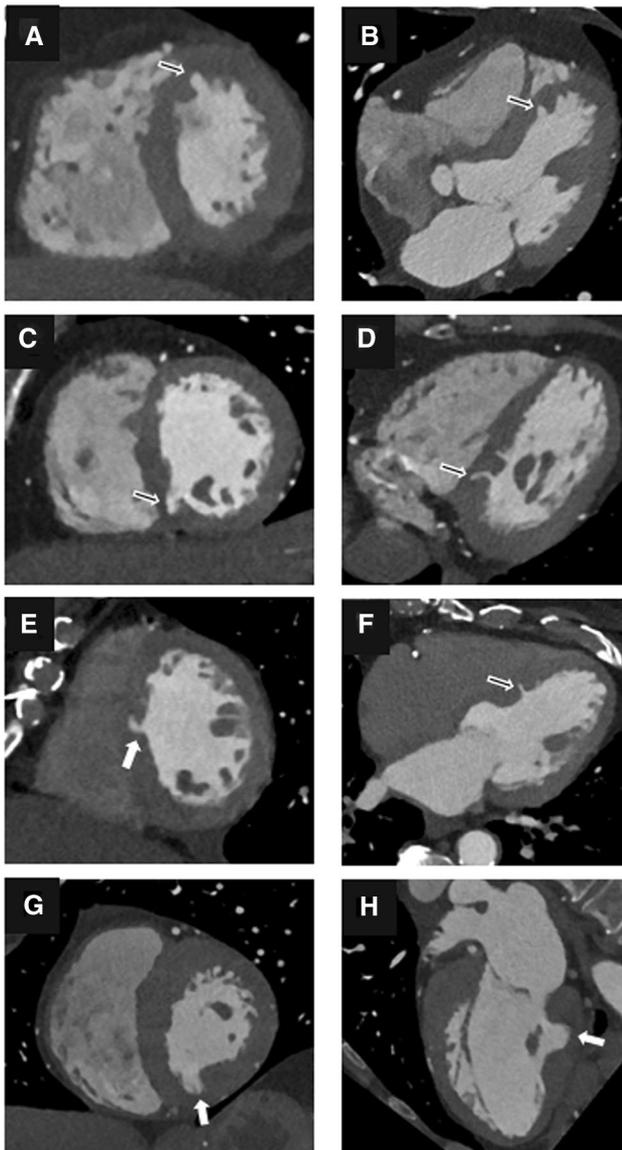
End-diastolic views in short and long axes for evaluation of myocardial crypts using CT. a, b normal subject; c, d patient with systemic hypertension; d, e patient with aortic valve stenosis; g, h patient with HCM. Note the greater length, width, and area of myocardial crypts in the inferobasal segment in the patient with HCM
